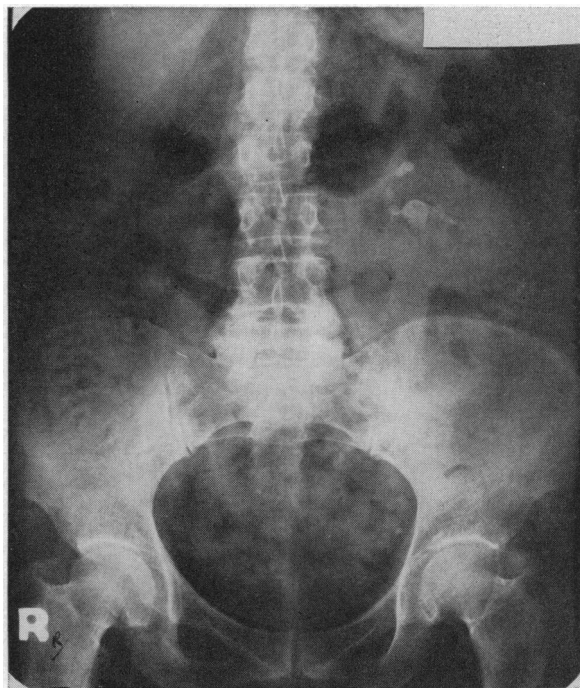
(Case 4).—Kidney-ureter-bladder x-ray film showing recurrent calculi in remaining kidney.
